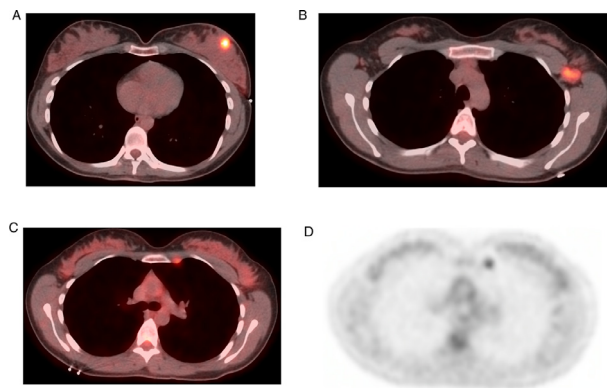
28-year-old female who initially presented with a palpable left breast mass and axillary lymphadenopathy. Ultrasound and mammographic workup was diagnostic for invasive ductal carcinoma with axillary metastasis. Axial fused PET-CT images (A and B) demonstrated hypermetabolic activity associated with the primary left breast mass and left axillary lymph nodes. Fused PET-CT and axial PET images (C and D) also identified a hypermetabolic left internal mammary lymph node.
